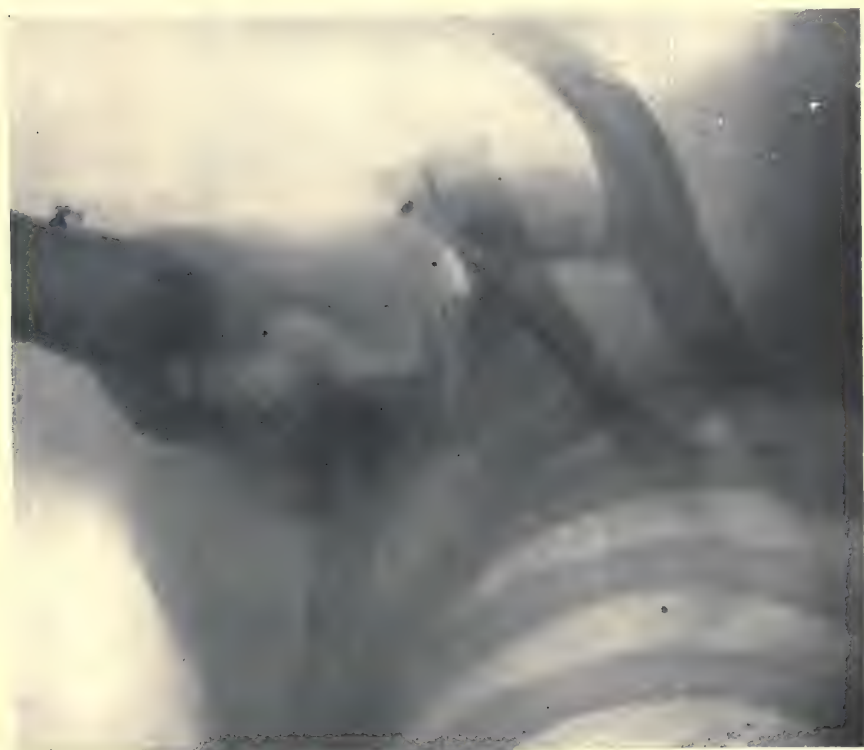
Case III.* X-ray showing ankylosis of scapula and humerus.
